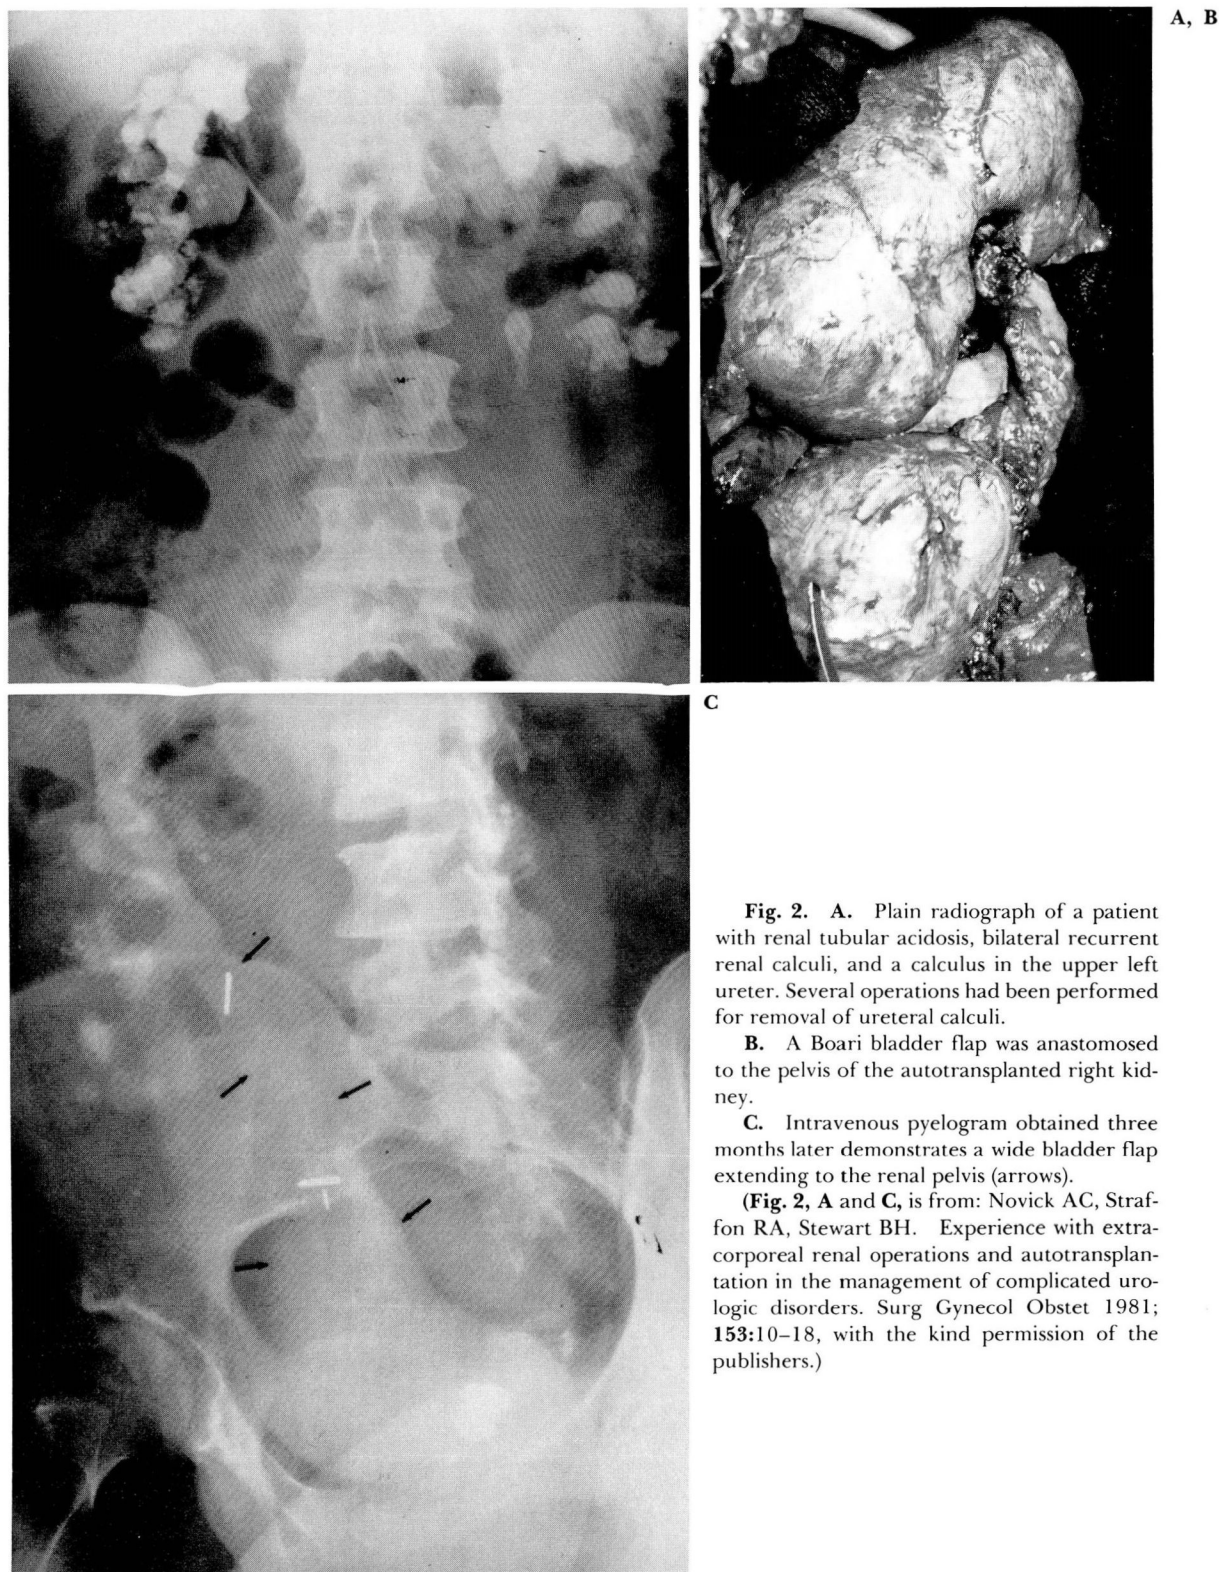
A. Plain radiograph of a patient with renal tubular acidosis, bilateral recurrent renal calculi, and a calculus in the upper left ureter. Several operations had been performed for removal of ureteral calculi.
